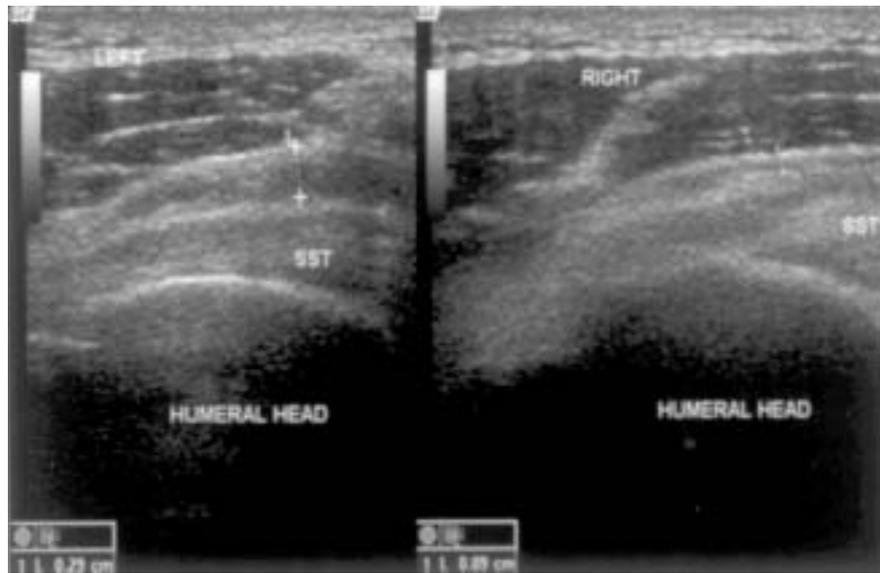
The 50-year-old male patient had left shoulder pain for 4 months. Ultrasonography revealed effusion in the left subacromial bursa. The left bursal thickness was 0.29 cm. The left supraspinatus showed more hypoechoogenicity than the right side and we considered it as Neer stage II impingement.
